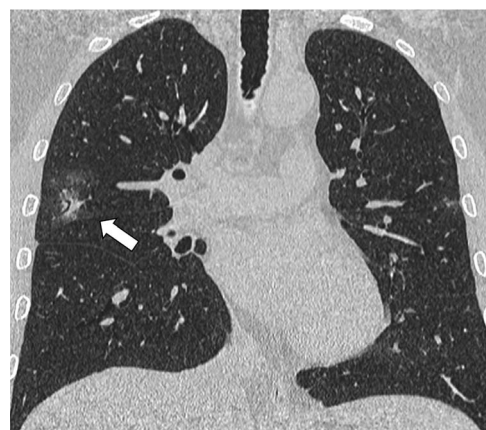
The HRCT scan of a 46-year-old male patient with a severity score of 6 showed consolidation at the right upper lobe, with the evidence of fibrosis, as manifested by the tract bronchiectasis.
